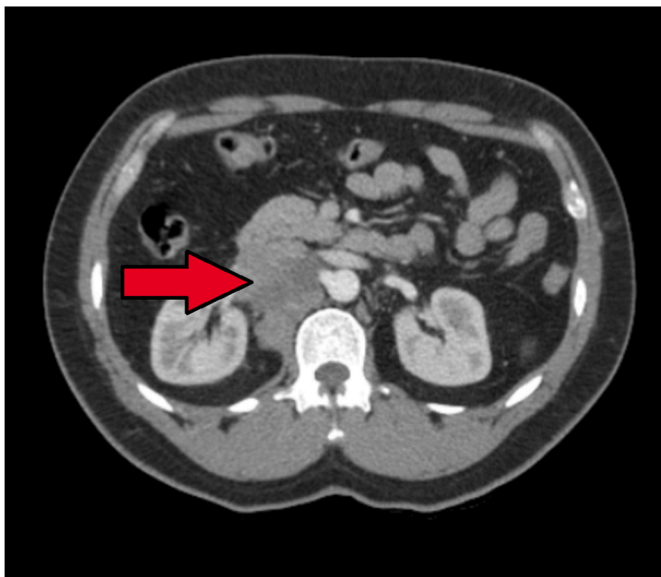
Abdominal contrasted computed tomography showing an adrenal tumor infiltrating renal parenchyma and renal vessels.
